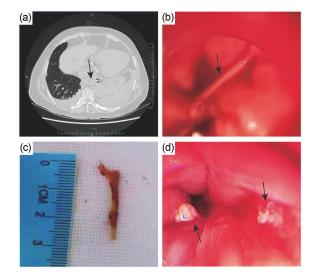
Images of the esophageal foreign body. (a) The chest computed tomography (CT) suggested a foreign body at the end of the esophagus (indicated by the black arrow). Gas accumulation on the left side and perforation was found, along with bilateral pneumonia, bilateral pleural effusion, and partial distension of the left lower lobe. (b) A foreign body (indicated by the black arrow) was inserted into the wall of the esophagus at 35 cm of the esophagus from the incisor, and produced pus emission. (c) The esophageal foreign body: a duck bone approximately 3 cm in length. (d) The mucosa of the upper esophagus was swollen after removal of the foreign body.
